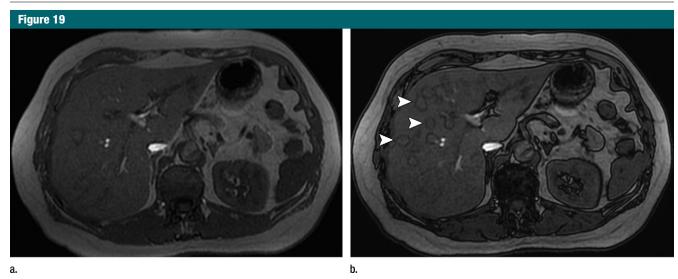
Images in a 66-year-old woman with pseudotumoral steatosis. (a) In- and (b) opposed-phase GRE T1-weighted MR images (236/2.2 and 4.4; flip angle, 80°; section thickness, 4 mm) show multiple small-sized lesions that drop in signal intensity on the opposed-phase image related to pseudotumoral steatosis (arrowheads). The presence of a more fatty border on the periphery of the lesions is highly suggestive of pseudotumoral steatosis.
